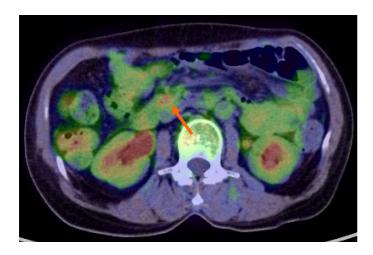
Pre-treatment 18 Fluorodeoxyglucose positron emission tomography/computed tomography images. 18 Fluorodeoxyglucose positron emission tomography/computed tomography showed abnormal nodular accumulation in the wall of the transverse part of the duodenum (arrow).
